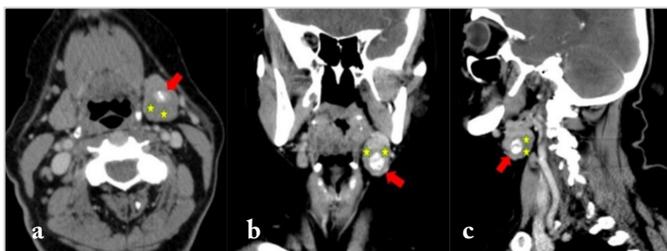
A calcified stone in the central part of the left submandibular gland (red arrow; AP×T×CC: 15×9×14 mm) in contrast-enhanced neck CT [a] axial, b) coronal, and c) sagittal planes]. A hypodense area (yellow stars) was observed that represent inflammatory-edematous changes caused by the stone. The left submandibular gland is larger than the right one
